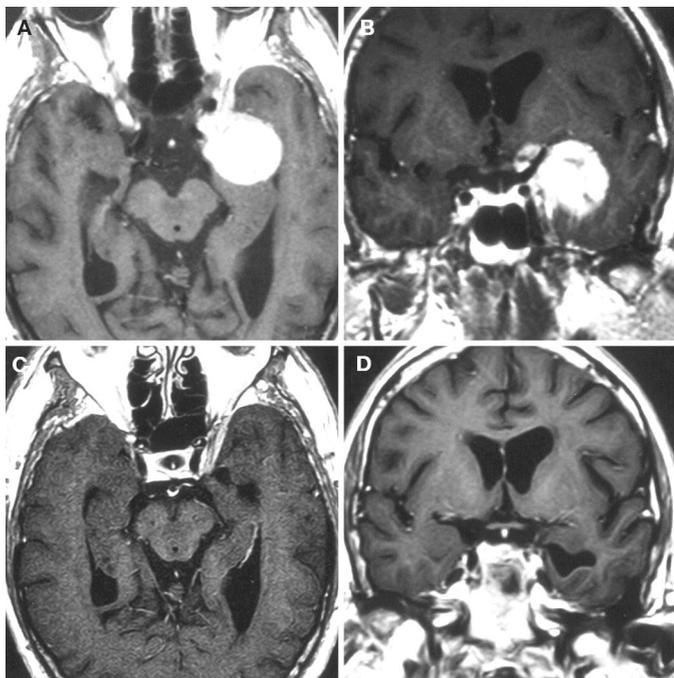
Preoperative and postoperative T1-weighted MRI investigation of a 57-year-old man who had a sphenoid wing meningioma on the left side. The preoperative images show a solid, homogeneous, encapsulated tumor incorporating the ICA bifurcation and compression of the optic chiasm (A and B). Note the tumor matrix on the anterior clinoid process. The postoperative images reveal complete tumor removal (C and D).
